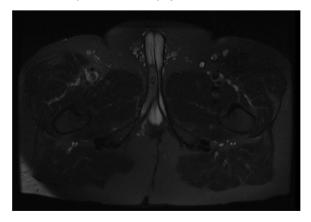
Axial view of follow-up MRI. MRI of the pelvis obtained four months after resuming imatinib demonstrated decrease in the size of the right corpus cavernosum mass from $8.4 \times 4.3 \times 3.6$ cm to $4.9 \times 1.8 \times 1.5$ cm.
